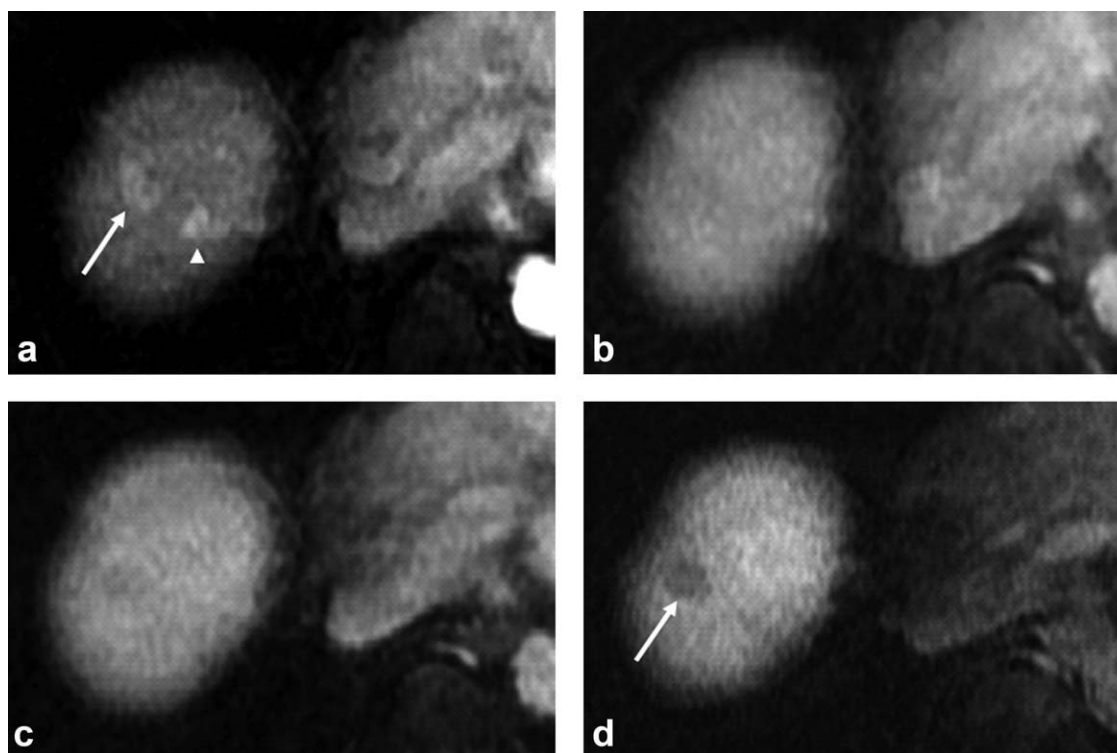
A 70-year-old man with a history of hepatitis C cirrhosis (Child-Pugh B) and biopsy-proven moderately differentiated HCC. Gd-EOB-enhanced arterial phase MR image shows a hypervascular nodule (arrow) at segment VIII (hepatic dome). Small A-P shunt (arrowhead) near the lesion is also seen on the Gd-EOB-enhanced arterial phase MR image. b,c: In Gd-EOB-enhanced portal venous and late phases MR images, the washout finding is unclear, with a score of 3 assigned by both readers. On the other hand, (d) the Gd-EOB-enhanced hepatobiliary phase MR image at 20 minutes clearly shows a hypointense nodule (arrow) at segment VIII (hepatic dome). Both readers judged this nodule as HCC (score of 5).
